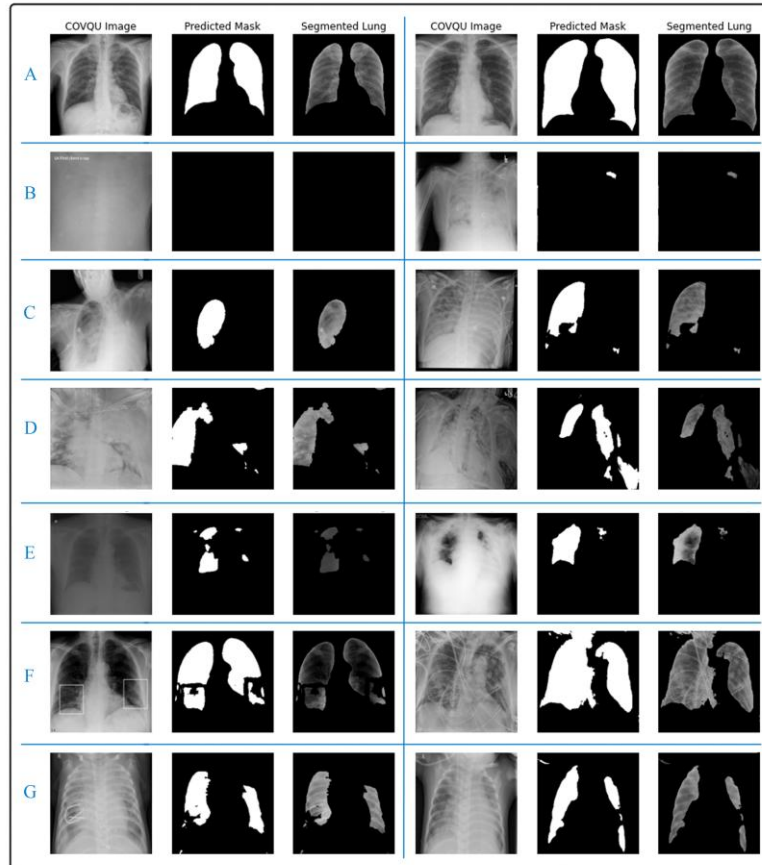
segmentation Failures for COVQU dataset, where A: Good quality X-ray images, B: Poor images, C: Unbalanced light, D: Bad shooting positions, E: Unclear and blurry images F: medical equipment or other signs, G: children X-ray images.
